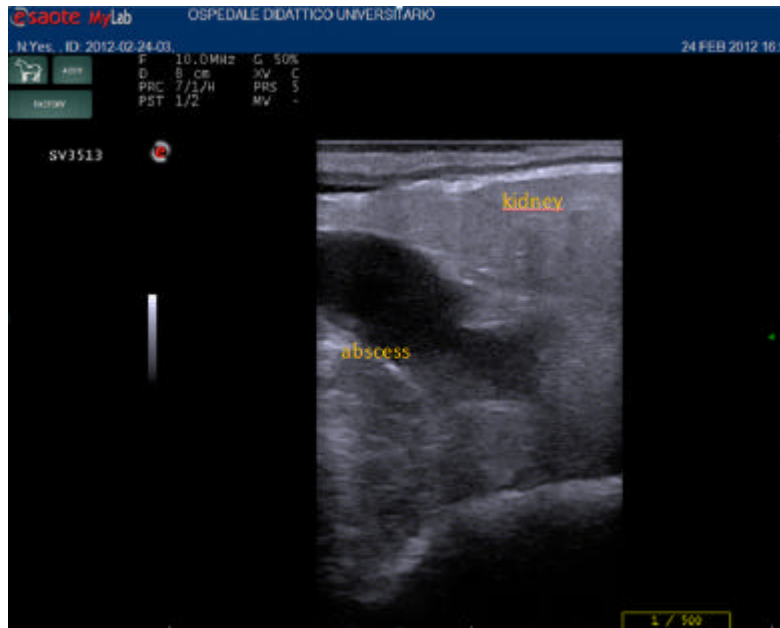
Trans-rectal ultrasonographic appearance of left kidney and abscess
